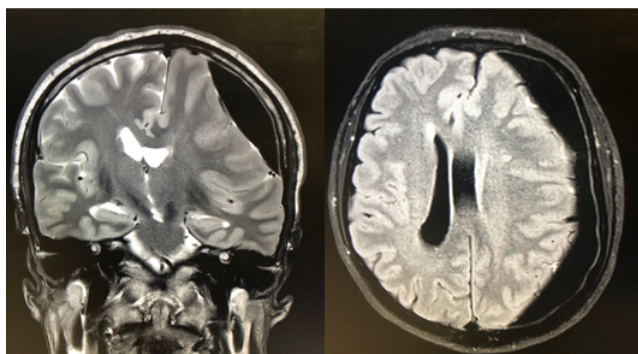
Coronal and sagittal images of patient MRI on day of admission.
